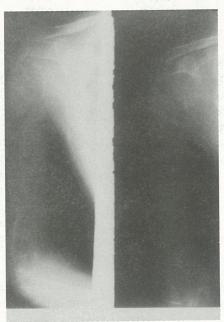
Radiographs one year after left arm fracture, showing massive dissolution of humerus, humeral head still visible.
